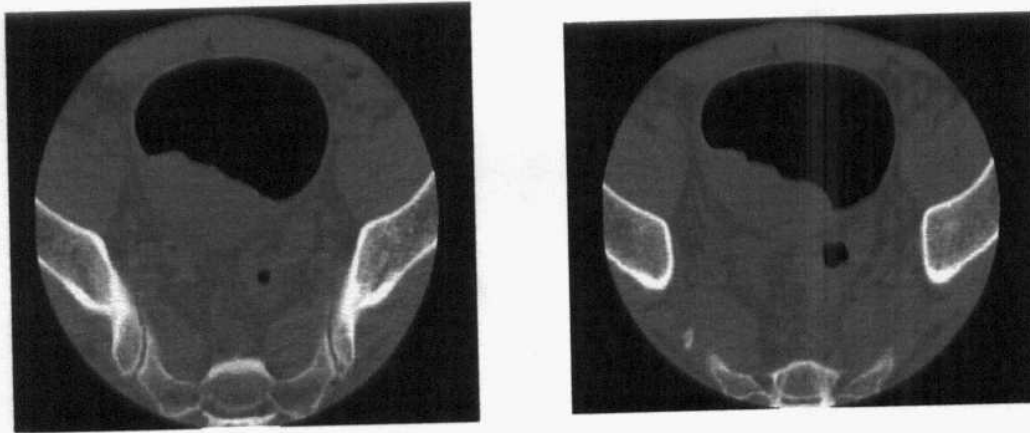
Axial CT with air contrast
